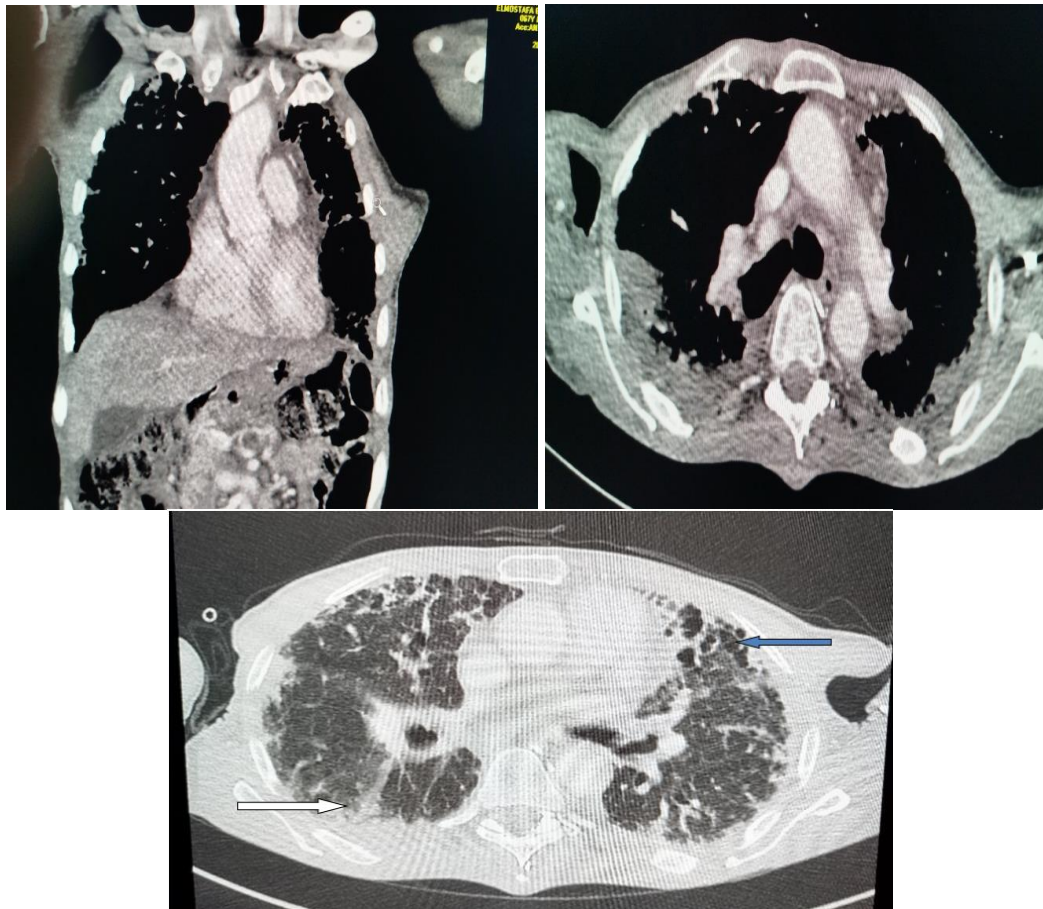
Chest CT scan showing tracheobronchomegaly associated with parietal tracheal diverticula; fibrosing diffuse interstitial pneumonia; minimal pneumomediastinum; minimal bilateral pleural effusion; minimal right apical pneumothorax
